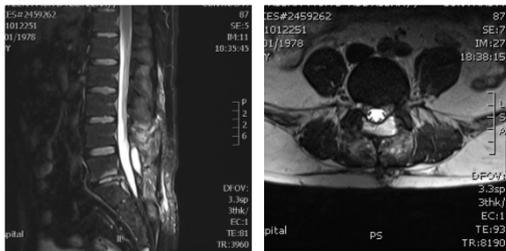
Post-operative MRI, Sagittal and axial cuts, demonstrating the presence of pseudomeningocele.
